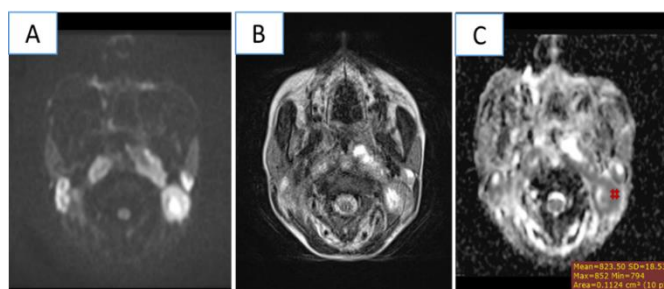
A 45-year-old female presented with bilateral neck lymphadenopathy. Axial views MRI A) T1WI, B) DWI 1000 and C) ADC images showed multiple enlarged lymph nodes with some showed central necrosis. The mean ADC value of the largest suspicious measured  $0.824 \times 10^{-3} \text{ mm}^2/\text{s}$ . Excisional biopsy revealed metastatic squamous cell CA
